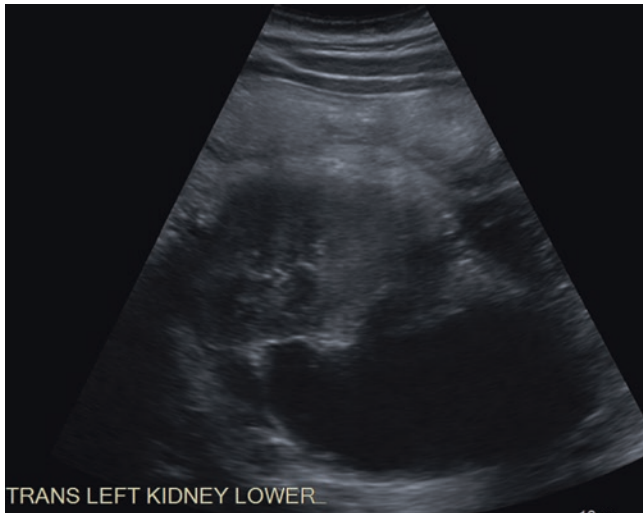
Longitudinal ultrasound image of a kidney performed 5 days after a high-grade renal injury shows development of a well-defined anechoic fluid collection, in keeping with a urinoma and indicative of injury to the renal collecting system
